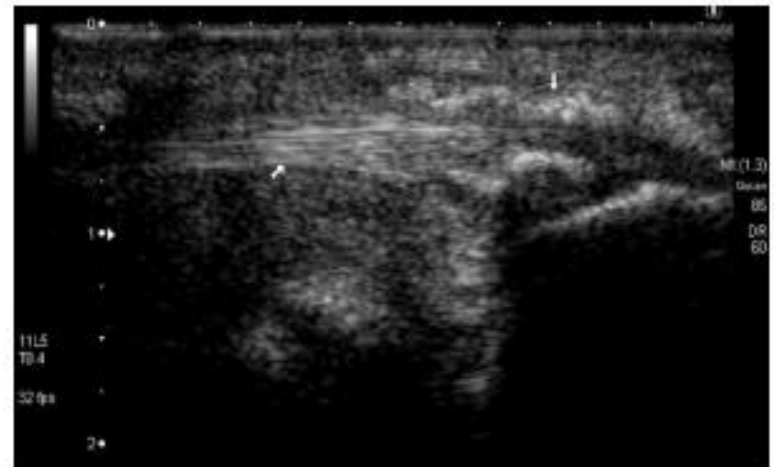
Ultrasonography image showing the linear tendon (oblique arrow) with hyperechoic structure in its distal portion consistent with calcification (straight arrow).
